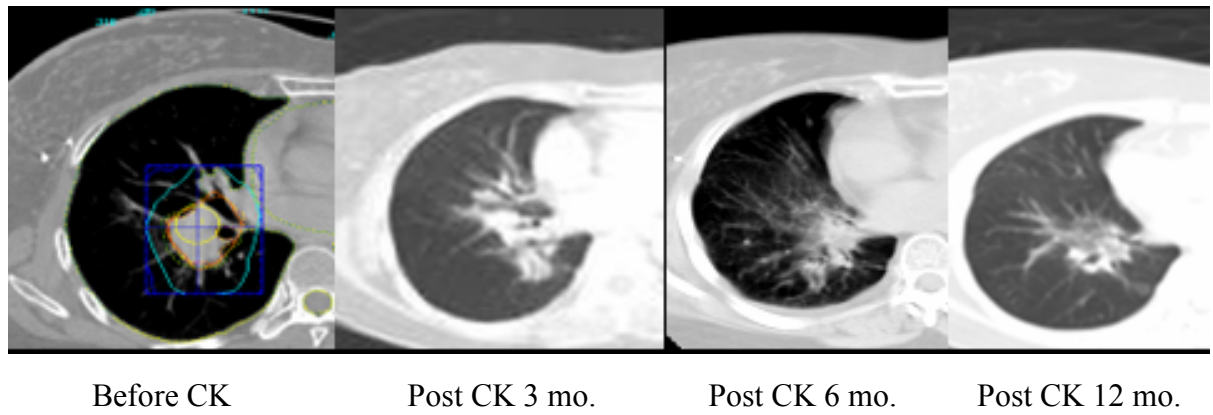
Serial follow-up CT images of a patient with solitary right lower lobe lung metastasis treated with CK SBRT, 36 Gy /3 fractions to 88% isodose
